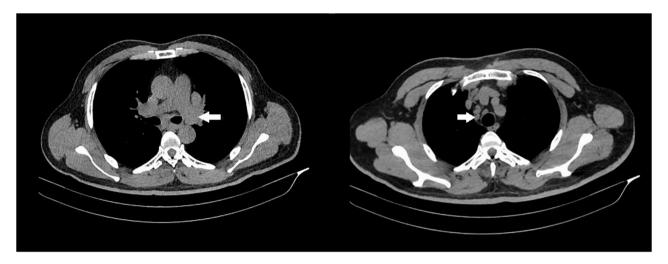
CT images of the chest showing bilateral hilar and mediastinal lymphadenopathy. White arrows indicate swelling lymph nodes.
